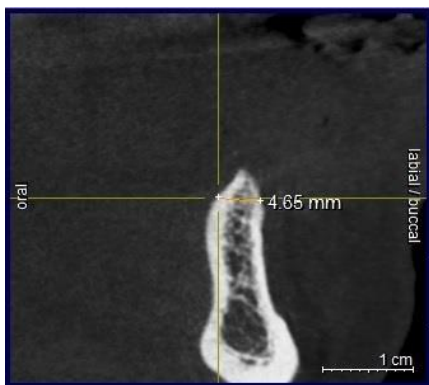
A CBCT coronal view showing a crestal width of 4.65 mm.
